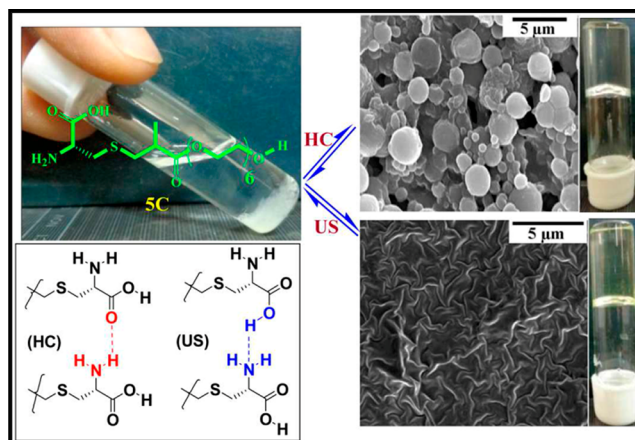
DMF gels of 5c obtained by ultrasound (US) and heating-cooling (HC) treatment showing different morphology and intermolecular hydrogen-bonding interactions among gelator molecules.
